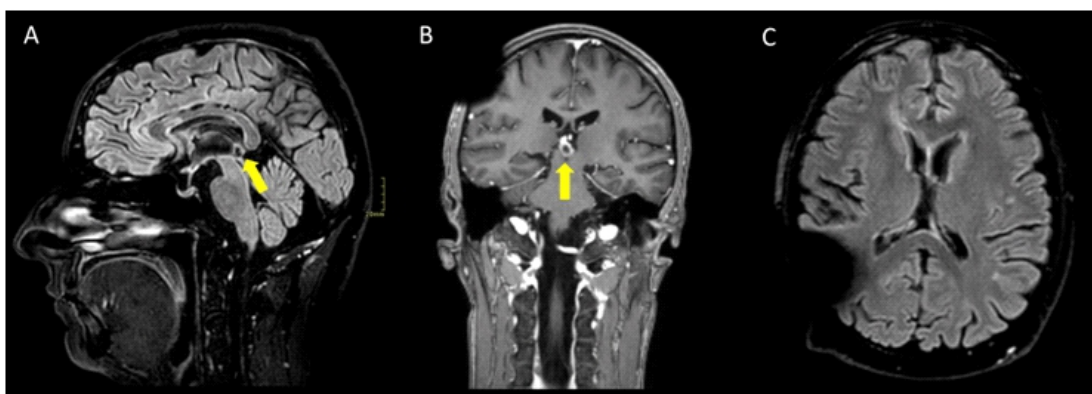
(A, B) Sagittal and coronal MR images after paramagnetic contrast enhancement showed pituitary lesion (yellow arrows) with size 15x17.7x19mm, with inferior growth towards the posterior portion of the third ventricle and involvement of the superior portion of the aqueduct. (C) Transaxial MR FLAIR image showed ventricular system in axis, of normal size and absence of areas of altered signal in the brain; ferromagnetic artifact is observed in the right parietal area.
